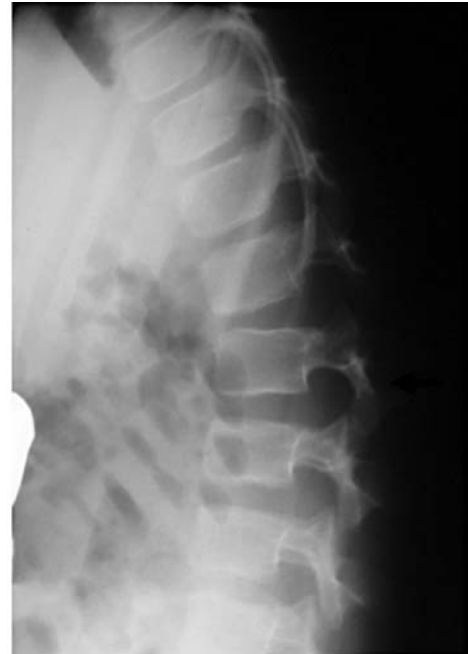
Dynamic X-rays performed in flexion confirmed instability at two levels (L1-L2 and L2-L3) by the increased height of the intervertebral foramina and by a widening of the posterior part of the intervertebral space
